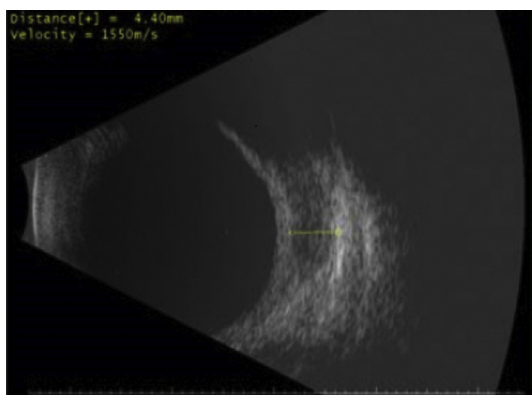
Bscan demonstrating fluid collection within Tenon's capsule and surrounding the scleral buckle at the equator on ocular ultrasound.
